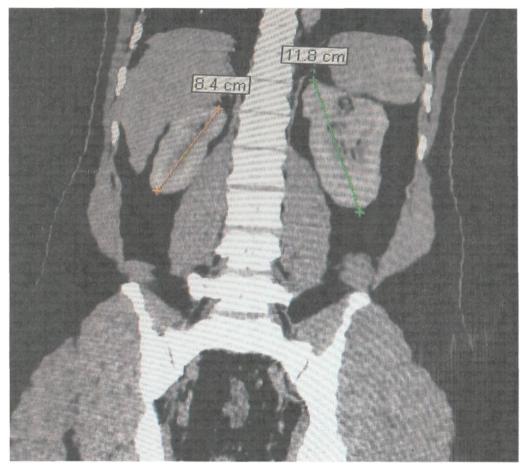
Coronal reformatted non-contrast computed tomogram showing the left kidney and the right upper kidney. The right upper kidney measured 8.2 cm in bipolar length while the left kidney measured 11.8 cm in bipolar length
